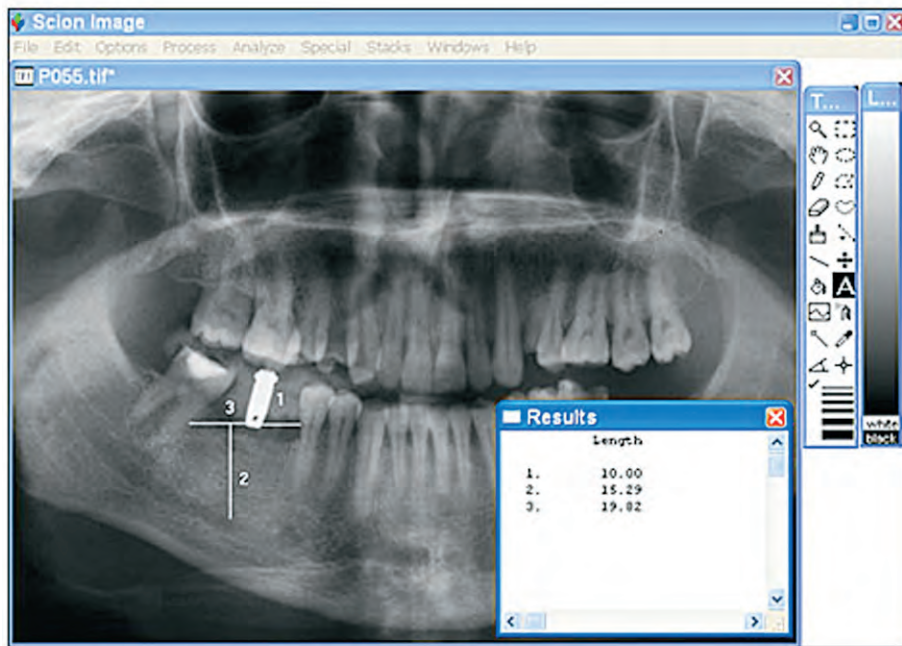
The radiograph showing the actual measurements based on the dummy implant.
